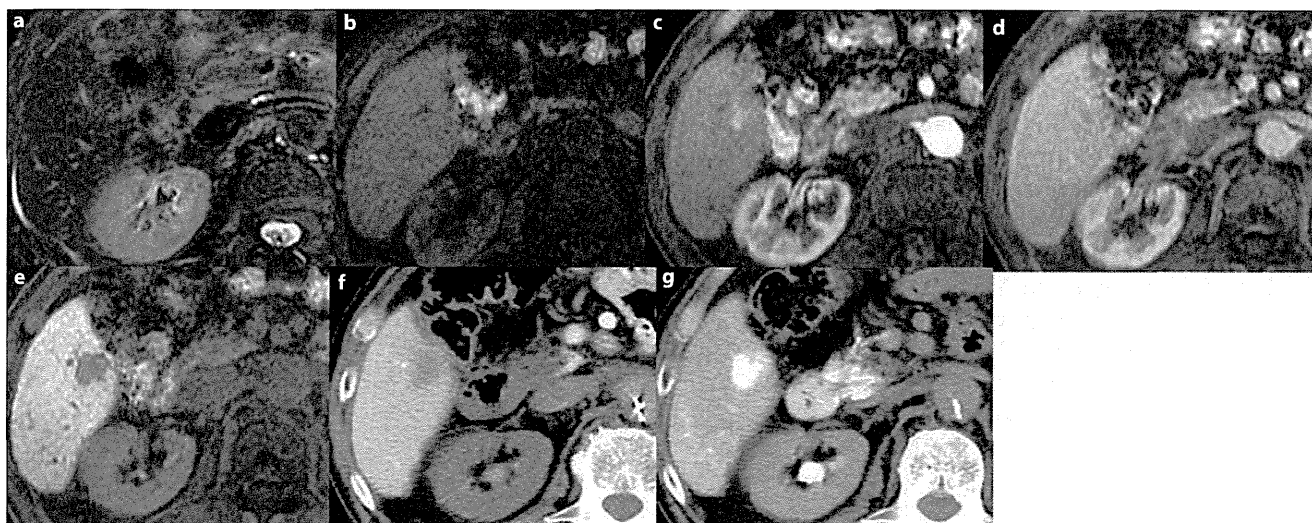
Gd-EOB-DTPA-enhanced MRI of hypervascular HCC in chronic hepatitis C: T<sub>1</sub>-weighted (in-phase) image (a), T<sub>1</sub>-weighted (opposed phase) (b), T<sub>2</sub>-weighted (c), precontrast 3DFT T<sub>1</sub>-weighted image (d), arterial phase (e), PVP (f), and hepatocyte phase (g). In-phase T<sub>1</sub>-weighted (a) and opposed phase T<sub>1</sub>-weighted images (b) reveal no fat deposition in the tumor. The tumor shows high intensity on the T<sub>2</sub>-weighted image (c). The tumor
